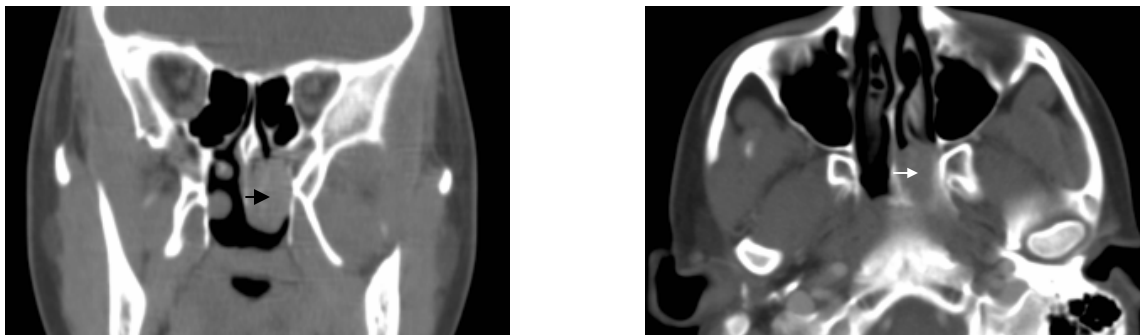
Coronal CT scan shows a mass filling left nasal cavity (*black arrow*).b. Axial CT scan filling left nasopharynx (*white arrow*).
